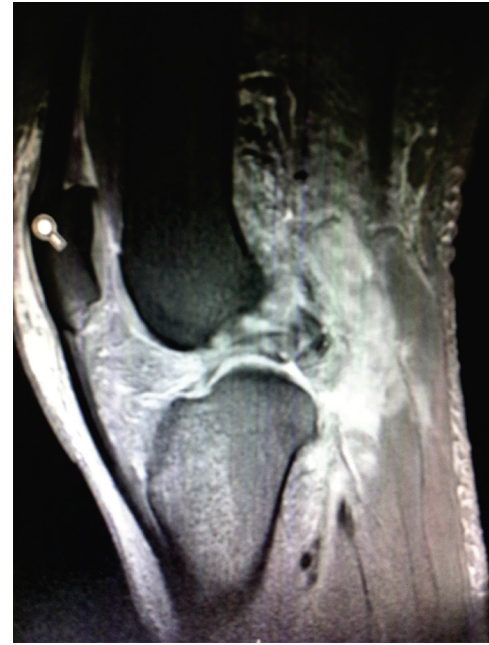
Magnetic resonance imaging of the initial lesion, showing the severe ligament injury.
